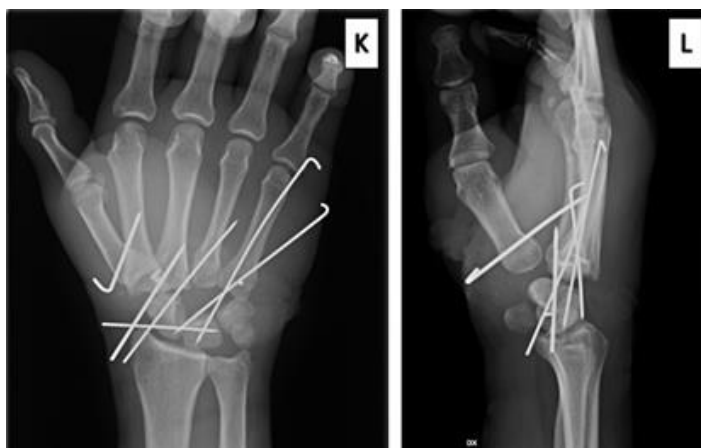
Postoperative radiographs reveal the successful fixation of MKK I, II, III, IV, and V using Kirschner wires, as depicted in (K) the PA projection and (L) the lateral projection.
